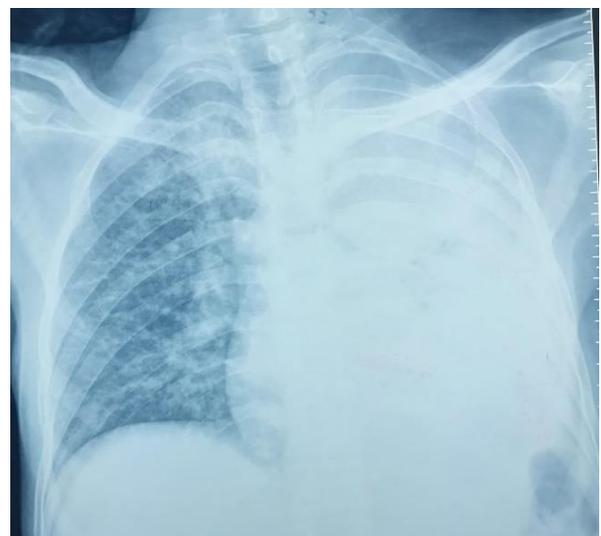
Chest x-ray showing dense opacity of the left hemithorax
